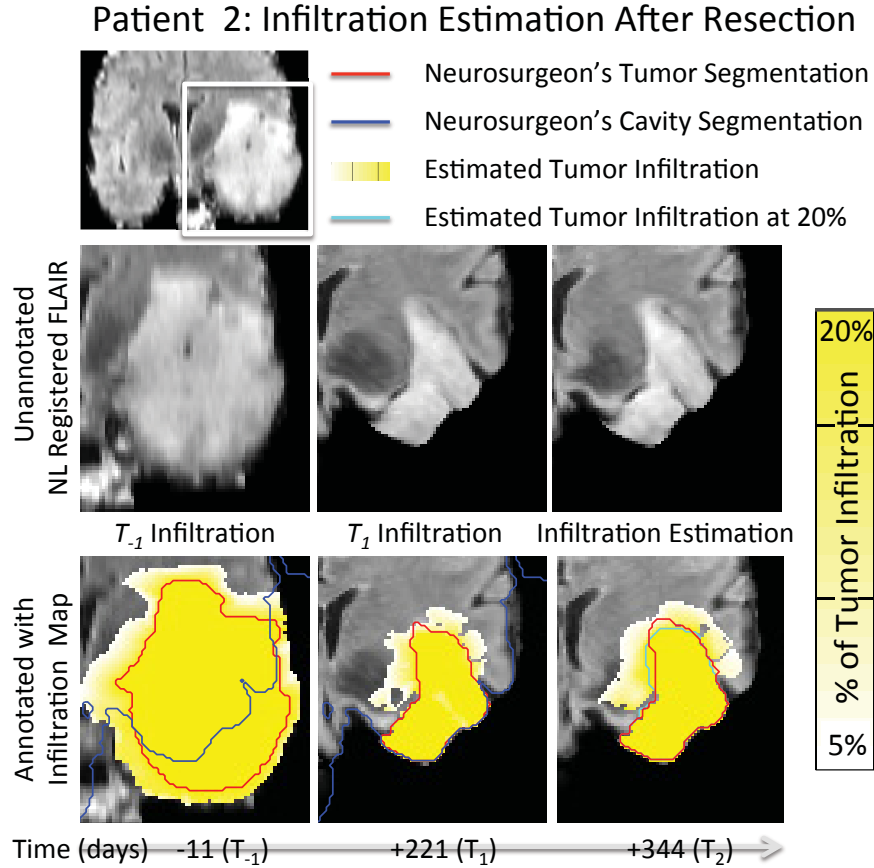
Infiltration maps for Patient 2 overlaid on the non-linearly registered FLAIR MRIs. From left to right: the infiltration map for  $T_{-1}$ , the infiltration map for  $T_1$ , and the tumor infiltration estimation at  $T_2$ .
